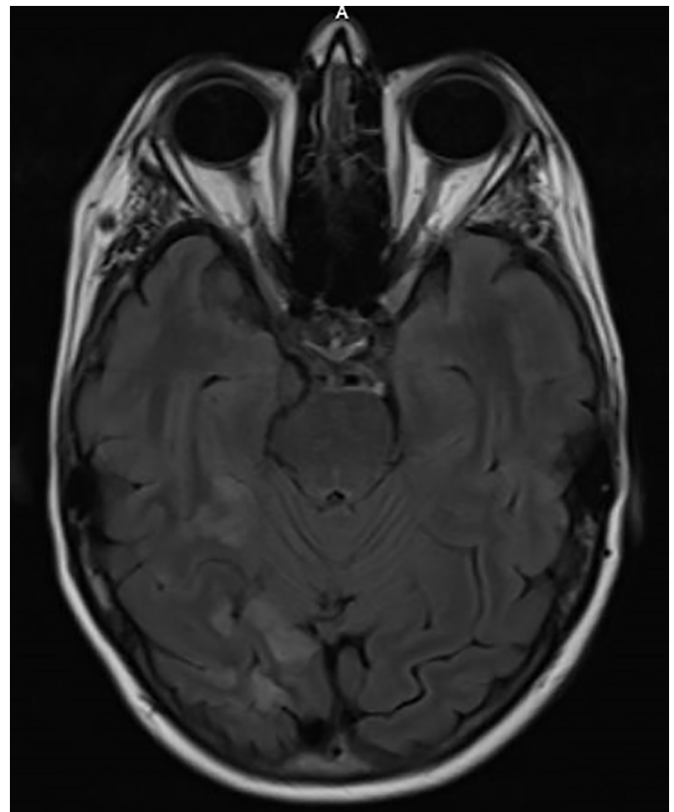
MRI brain with and without contrast demonstrating multiple foci of restricted diffusion predominantly in the right occipital lobe, consistent with right posterior cerebral artery distribution subacute infarct.
